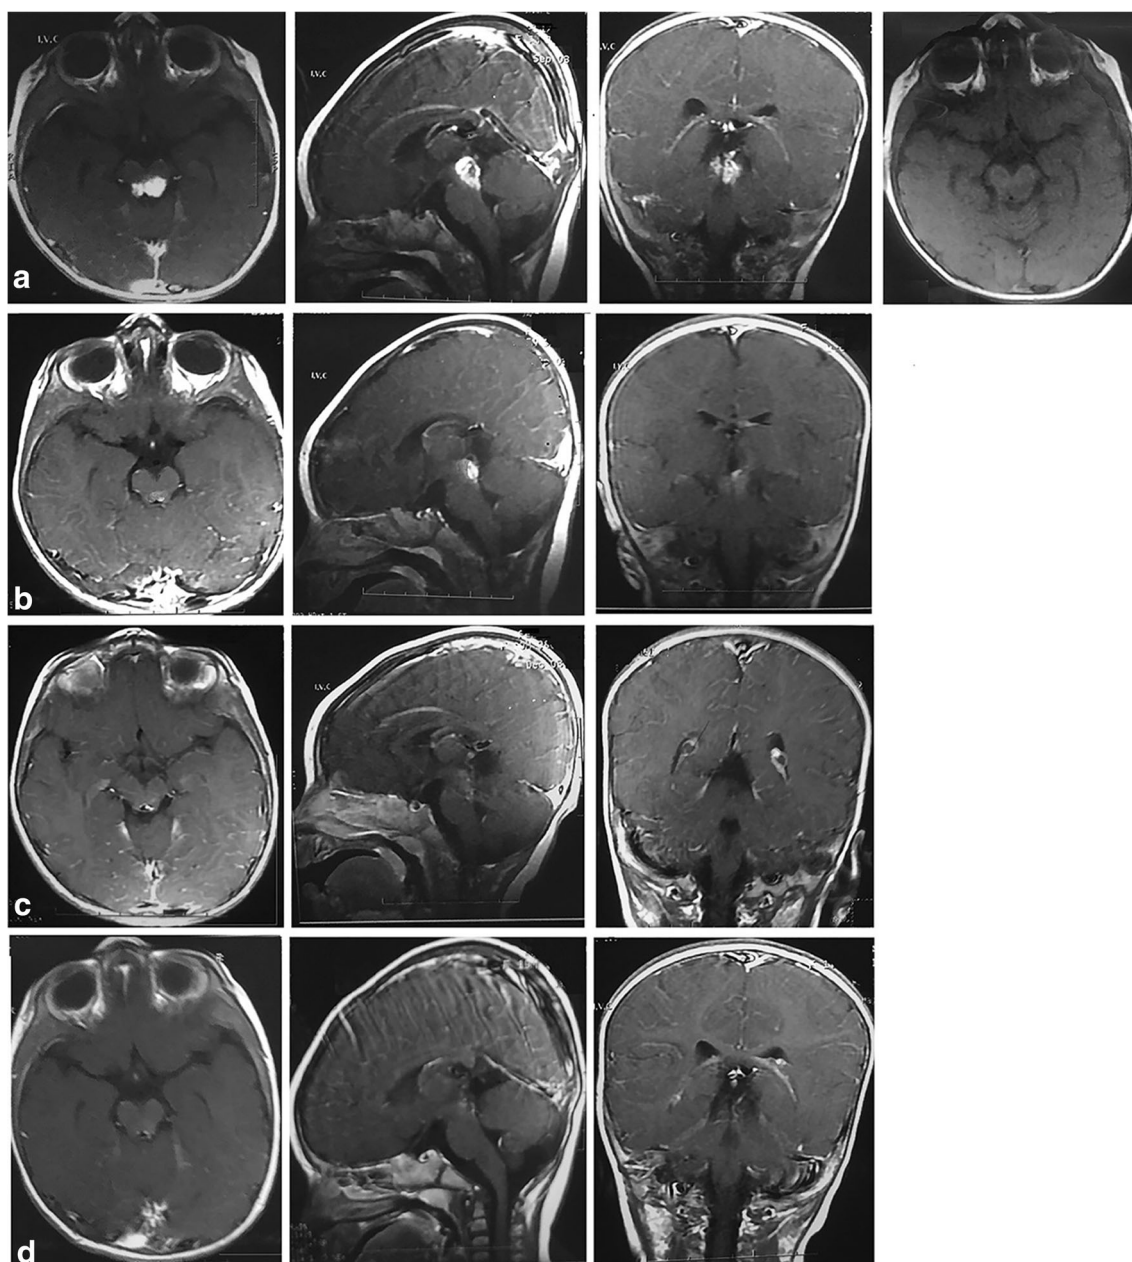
Axial, sagittal, and coronal MRI images of the tectal plate mass at the age of 2 months (a), 4 months (b), 8 months (c), and 18 months (d) showing decrease in the size and enhancement of the lesion. In the top
